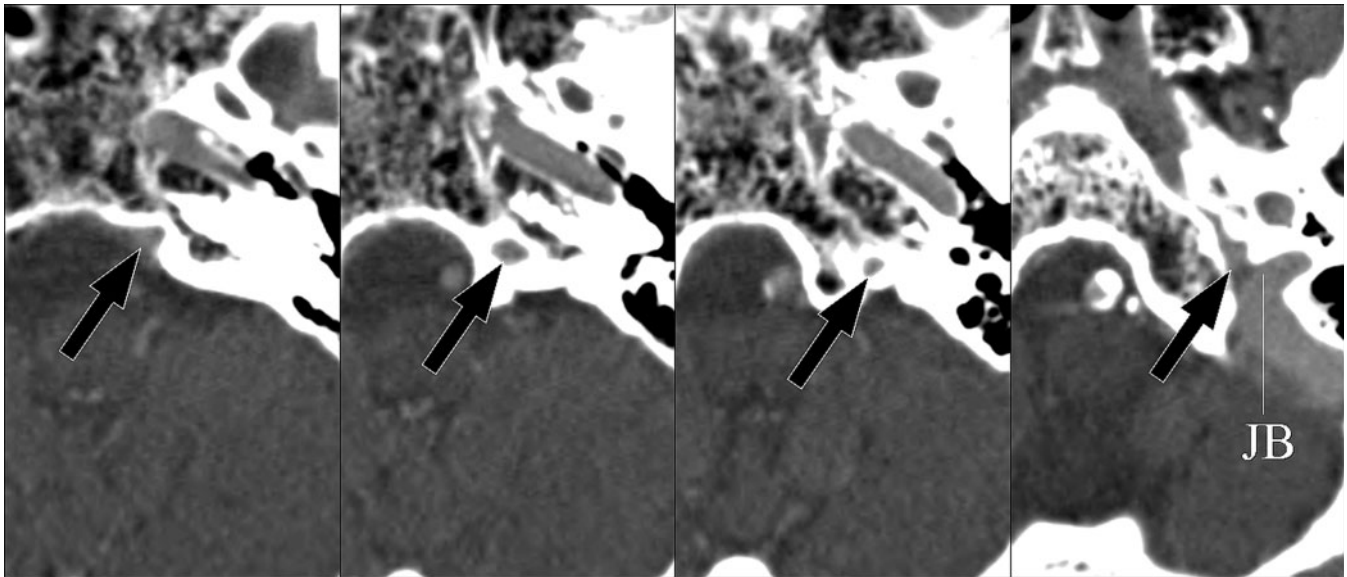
Type A inferior petrosal sinus (IPS). A 79-year-old female with lung cancer. Axial CT images showing the IPS (black arrows), which originates from the posterosuperior part of the cavernous sinus (CS), runs along the petroclival fissure and drains into the jugular bulb (JB).
